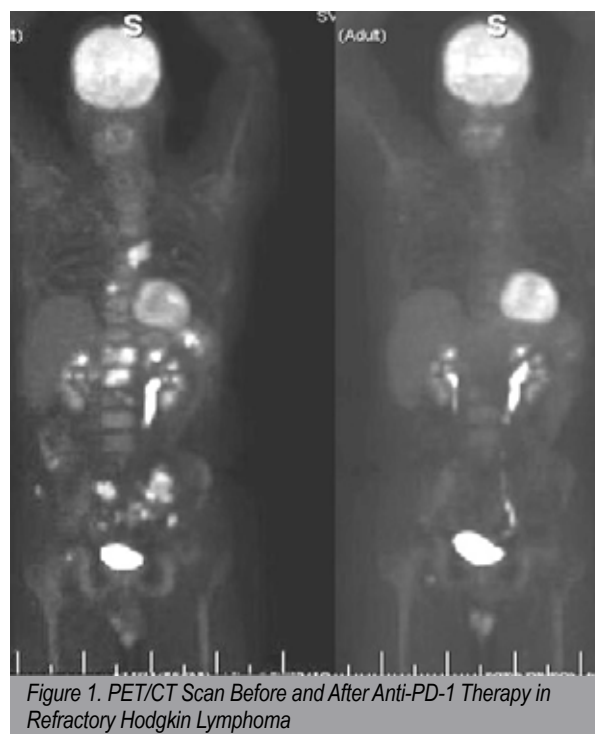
PET/CT Scan Before and After Anti-PD-1 Therapy in Refractory Hodgkin Lymphoma
